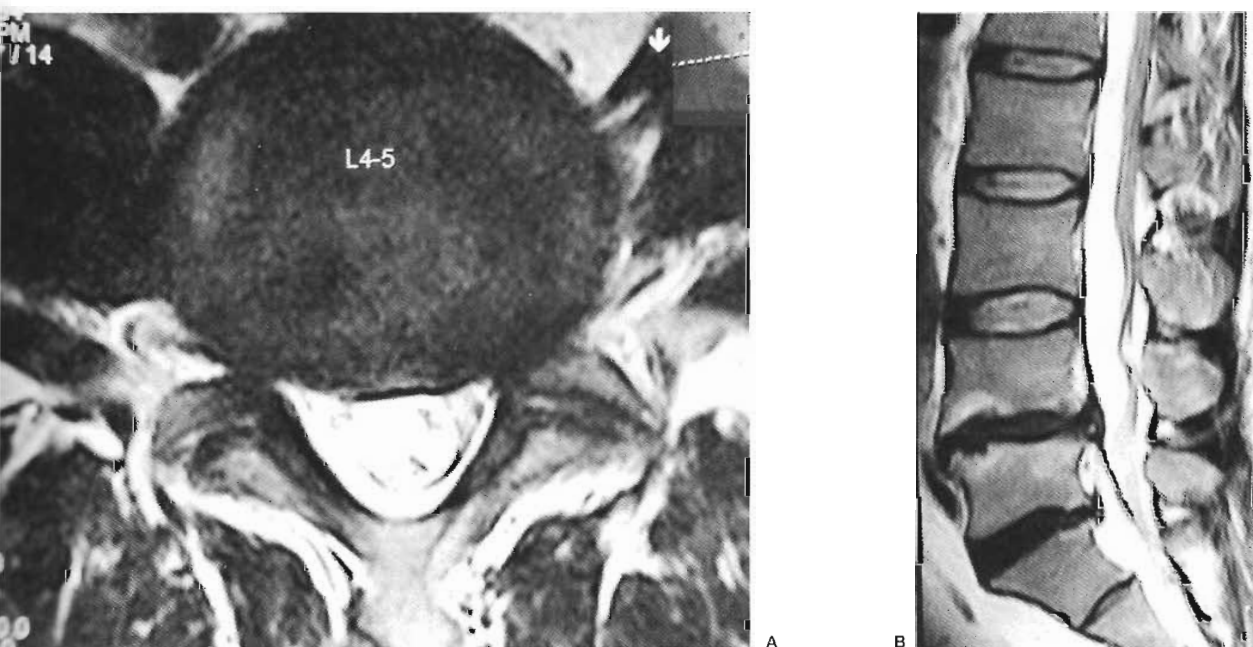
T2 weighted MRI image demonstrating near total resolution of disc prolapse.
